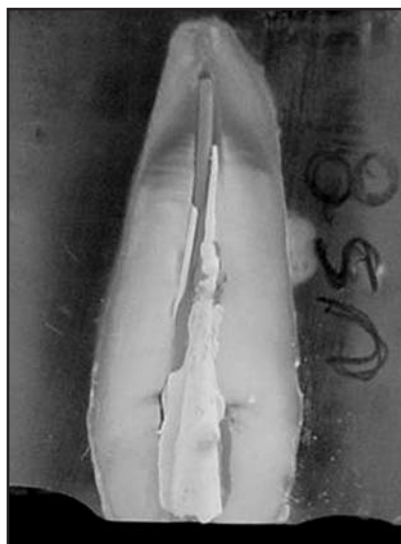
Ultrasound ENAC technique.
